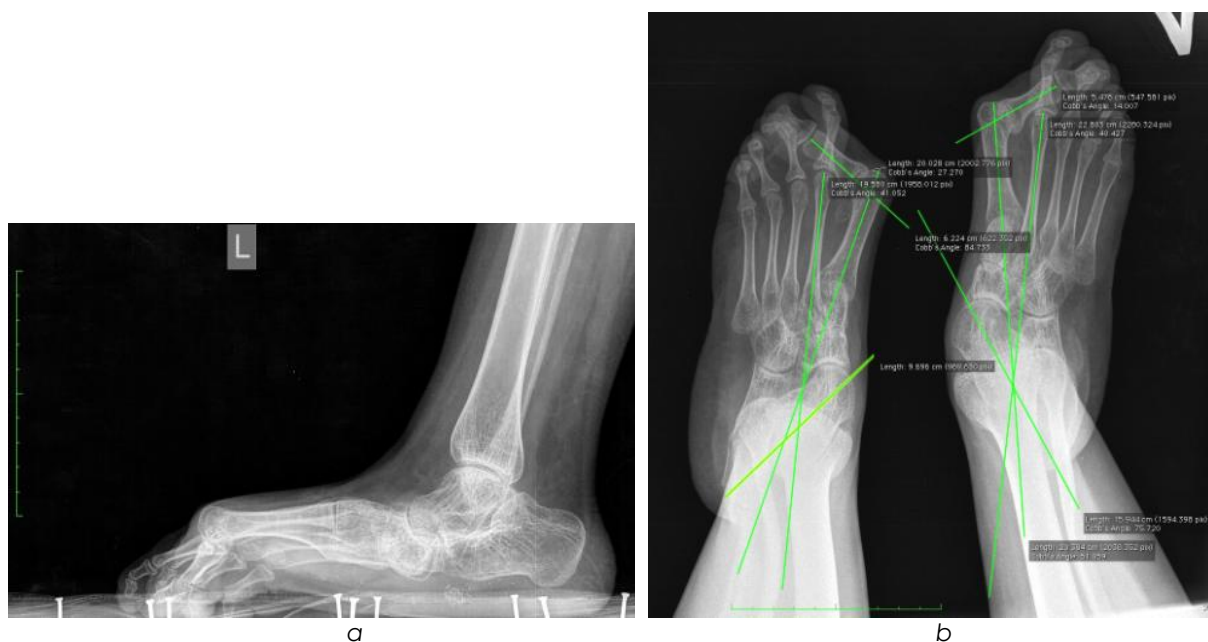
X-ray of the feet in a patient with neuromuscular planovalgus deformity: a - in the lateral projection; b - in the frontal projection.
